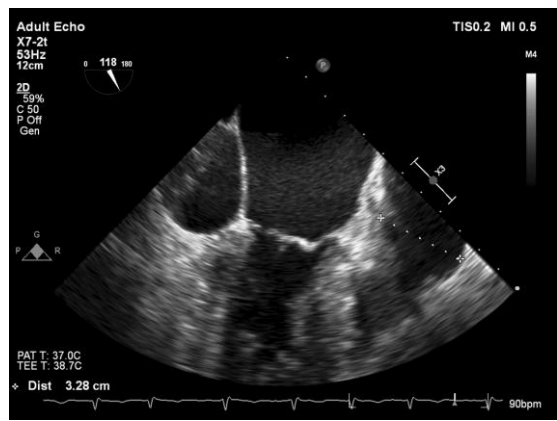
Transesophageal echocardiography showing enlarged coronary sinus – 32×19 mm.
